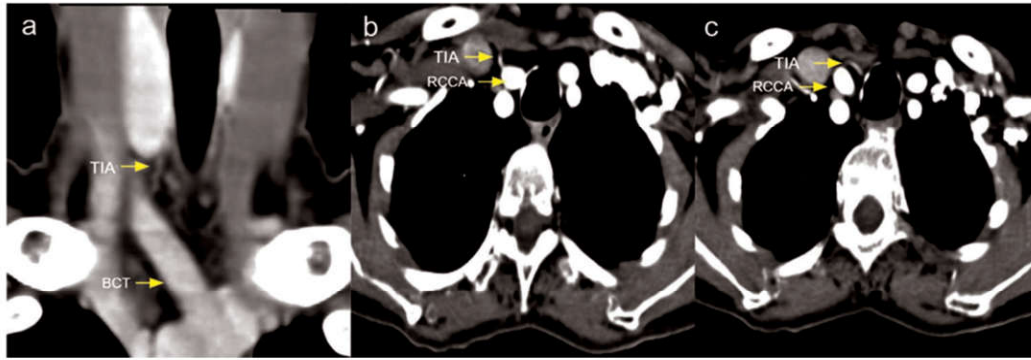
Coronal CT neck contrast image (1a) showing thyroidea ima artery arising from the brachiocephalic trunk.
